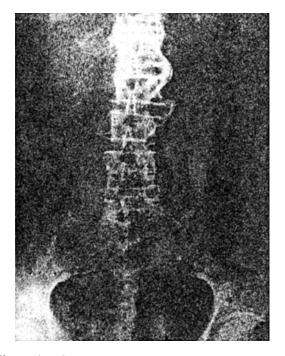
Plain film taken on the first postoperative day shows small stone fragments in the upper ureter
